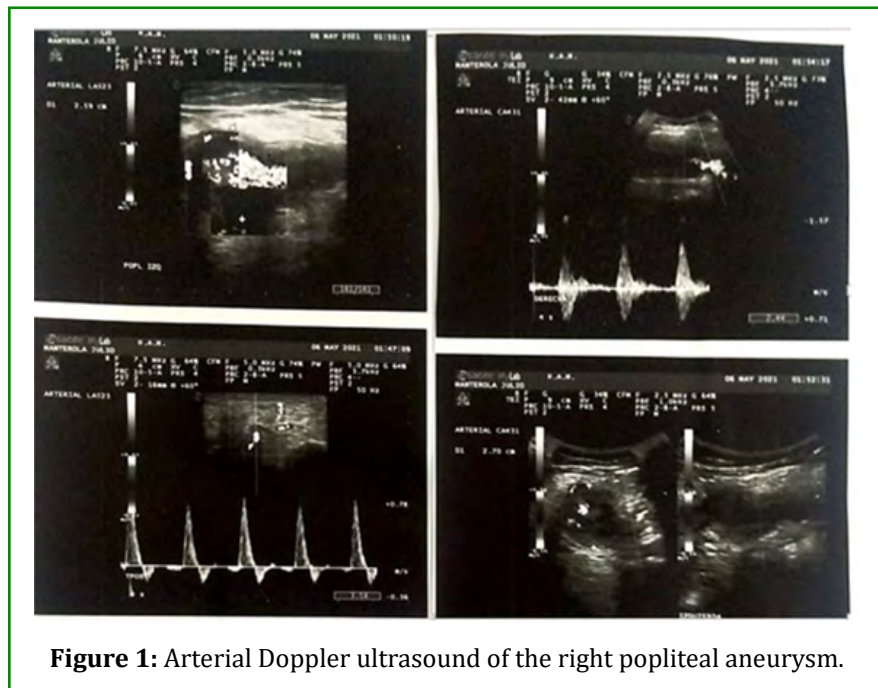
Arterial Doppler ultrasound of the right popliteal aneurysm.
